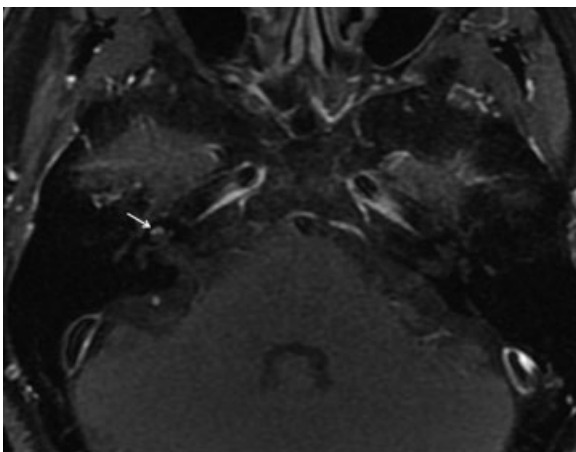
Axial postcontrast T1-weighted image showing enhancement in the modiolus (arrow) of the right cochlea.
